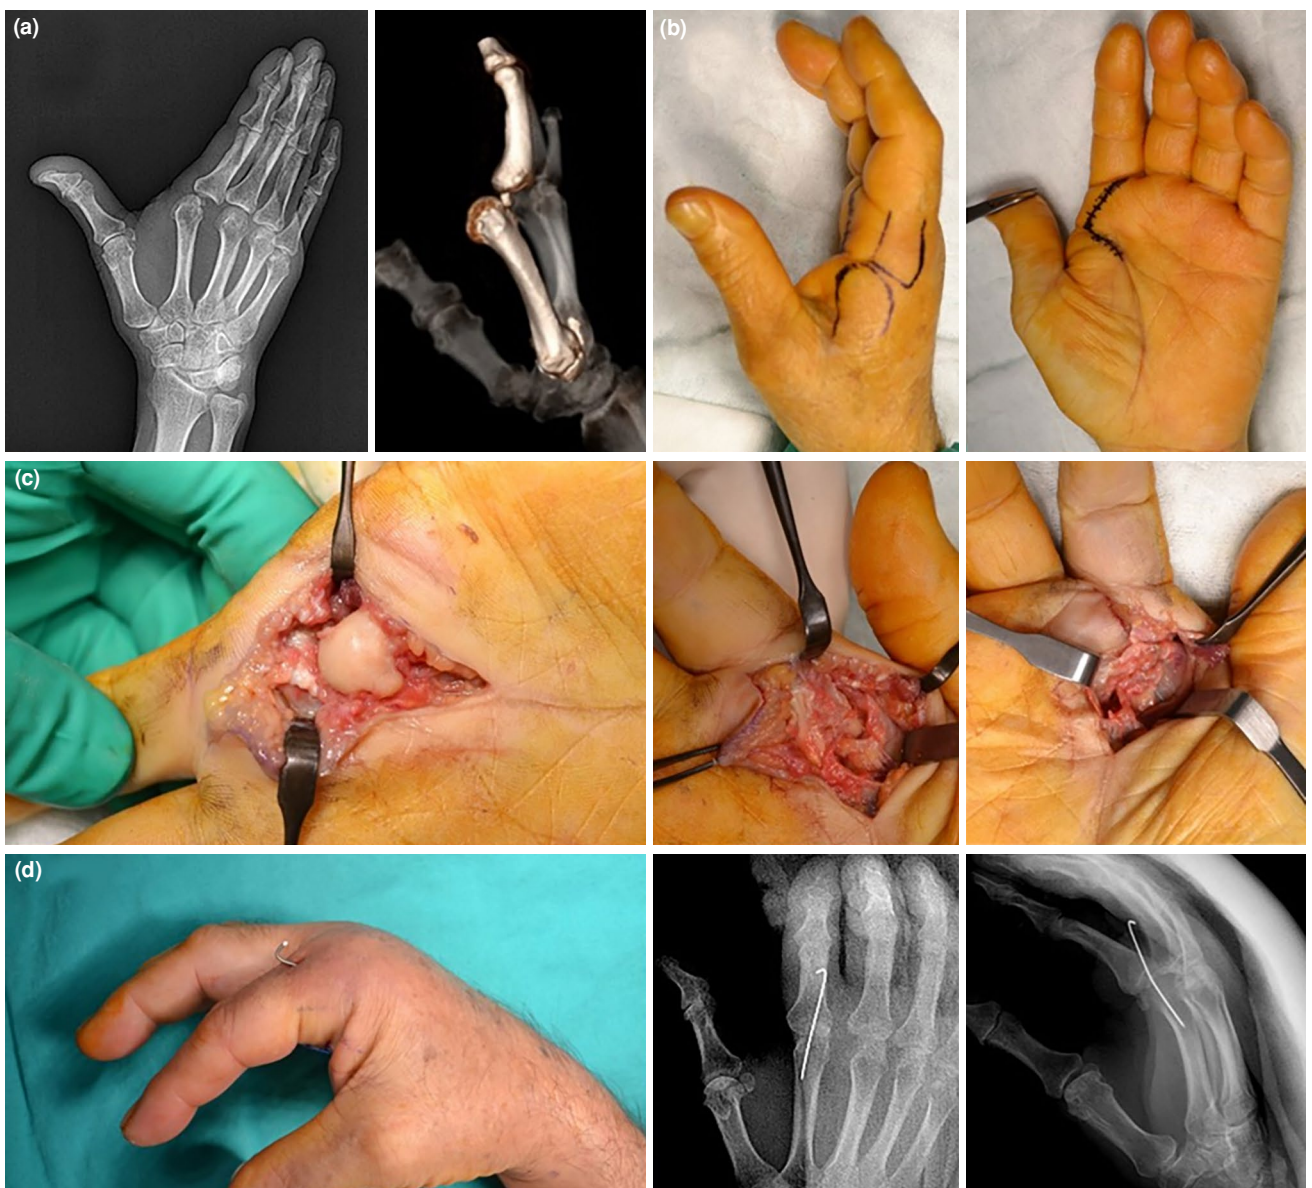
Volar approach for irreducible MCP dislocation. (a) Preoperative radiograph and CT image demonstrating MCP joint dislocation. (b) Preoperative view of volar surgical approach. (c) Intraoperative view showing volar exposure of the MCP joint. (d) Post-reduction images depicting morphological alignment and radiographic confirmation following K-wire fixation.
